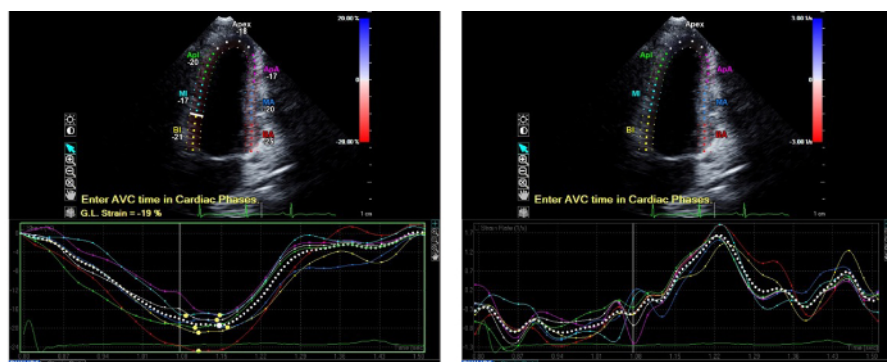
Apical 2-chamber view-derived longitudinal strain and strain rate. Left and right panels show Apical 2-chamber (AP2) derived LV myocardial ϵ and SR, respectively. Time-strain curves correspond to the color-coded segments as described above for Figure 1. [Please click here to view a larger version of this figure.](#)
